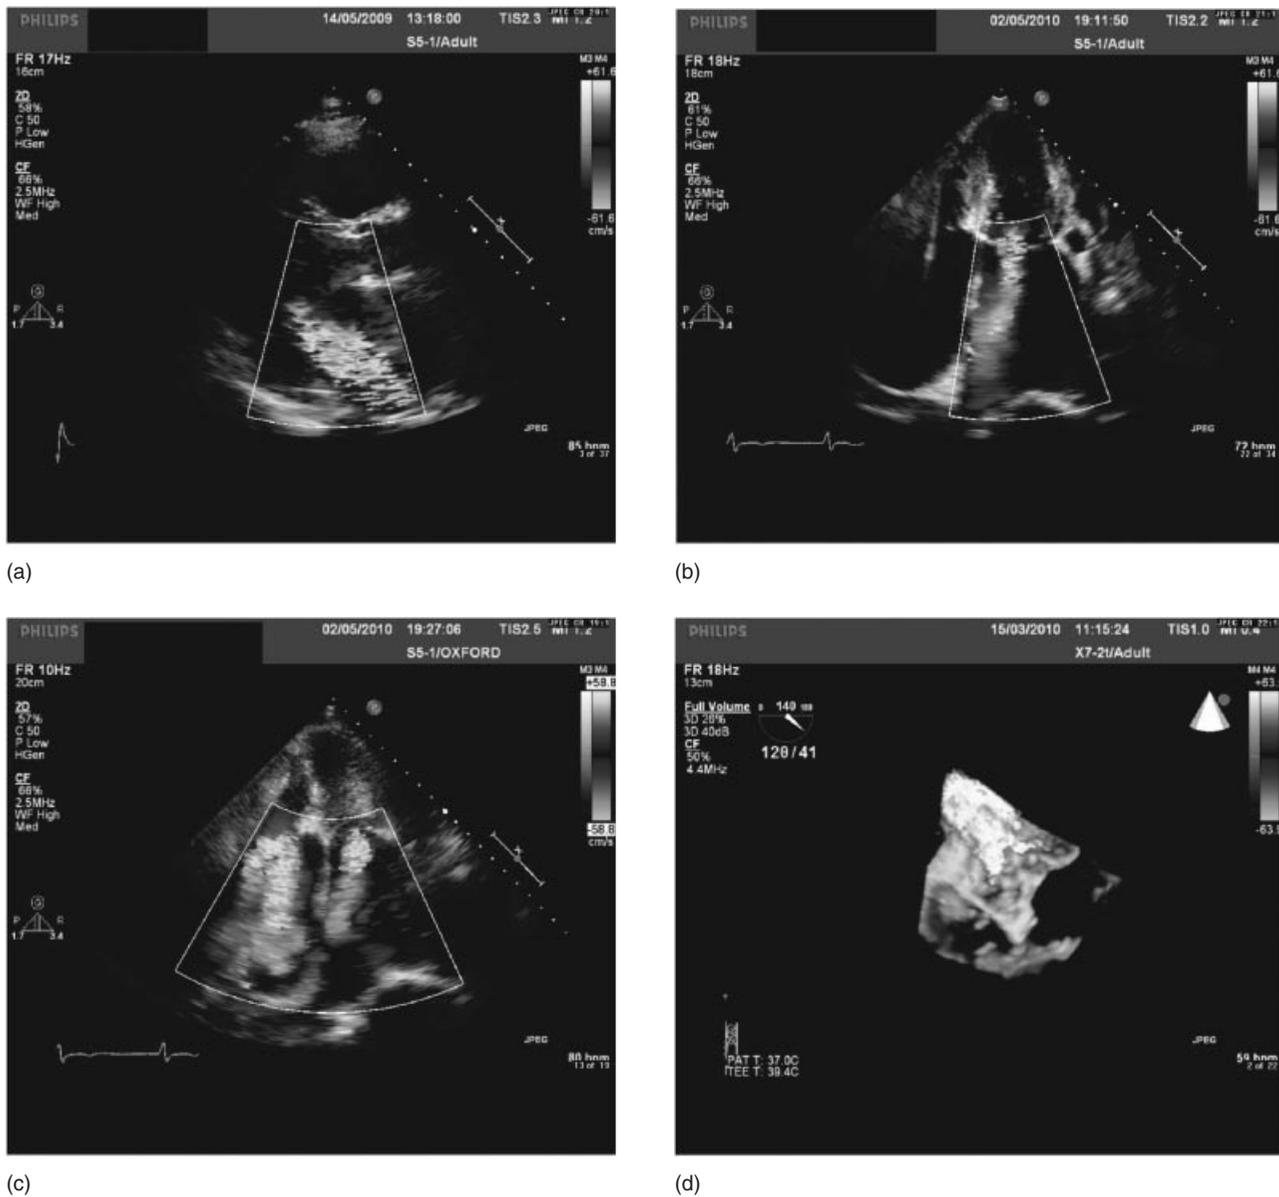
(a) TTE parasternal long-axis view with a broad colour jet across the mitral valve demonstrating severe mitral regurgitation. (b) TTE apical view demonstrating severe mitral regurgitation; the broad colour jet occupies over one-third of the left atrium. (c) TTE apical view demonstrating torrential tricuspid regurgitation and concurrent severe mitral regurgitation, causing biatrial dilatation. (d) 3D TOE demonstrating severe mitral regurgitation. See plate section for a colour version of this image.
